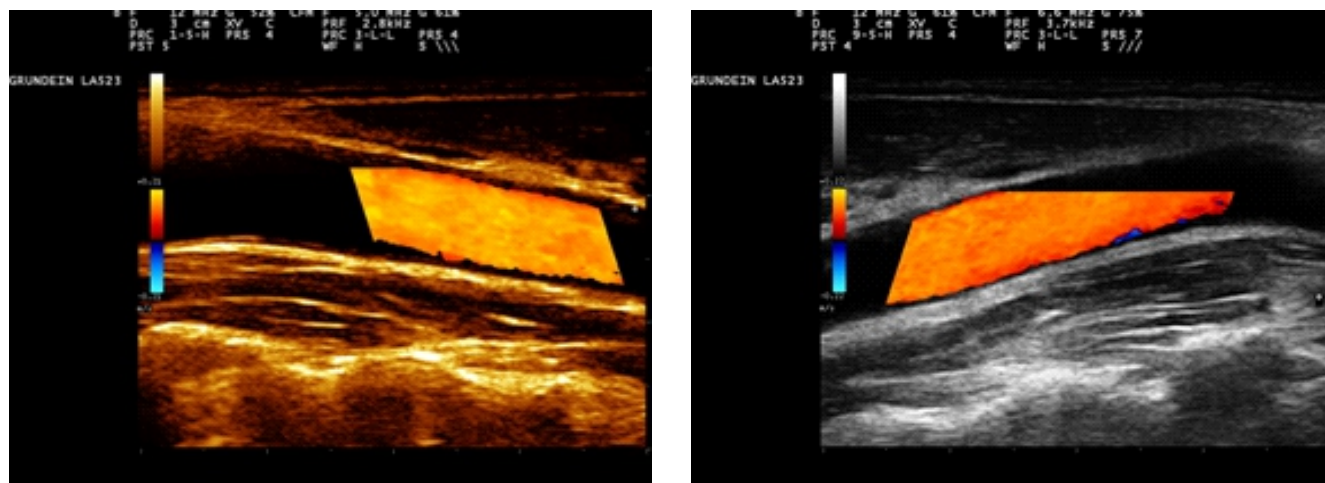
Longitudinal color Doppler flow mode image of the CCA - with orange and blue Gray filters for better evidence of blood flow and vessel wall
